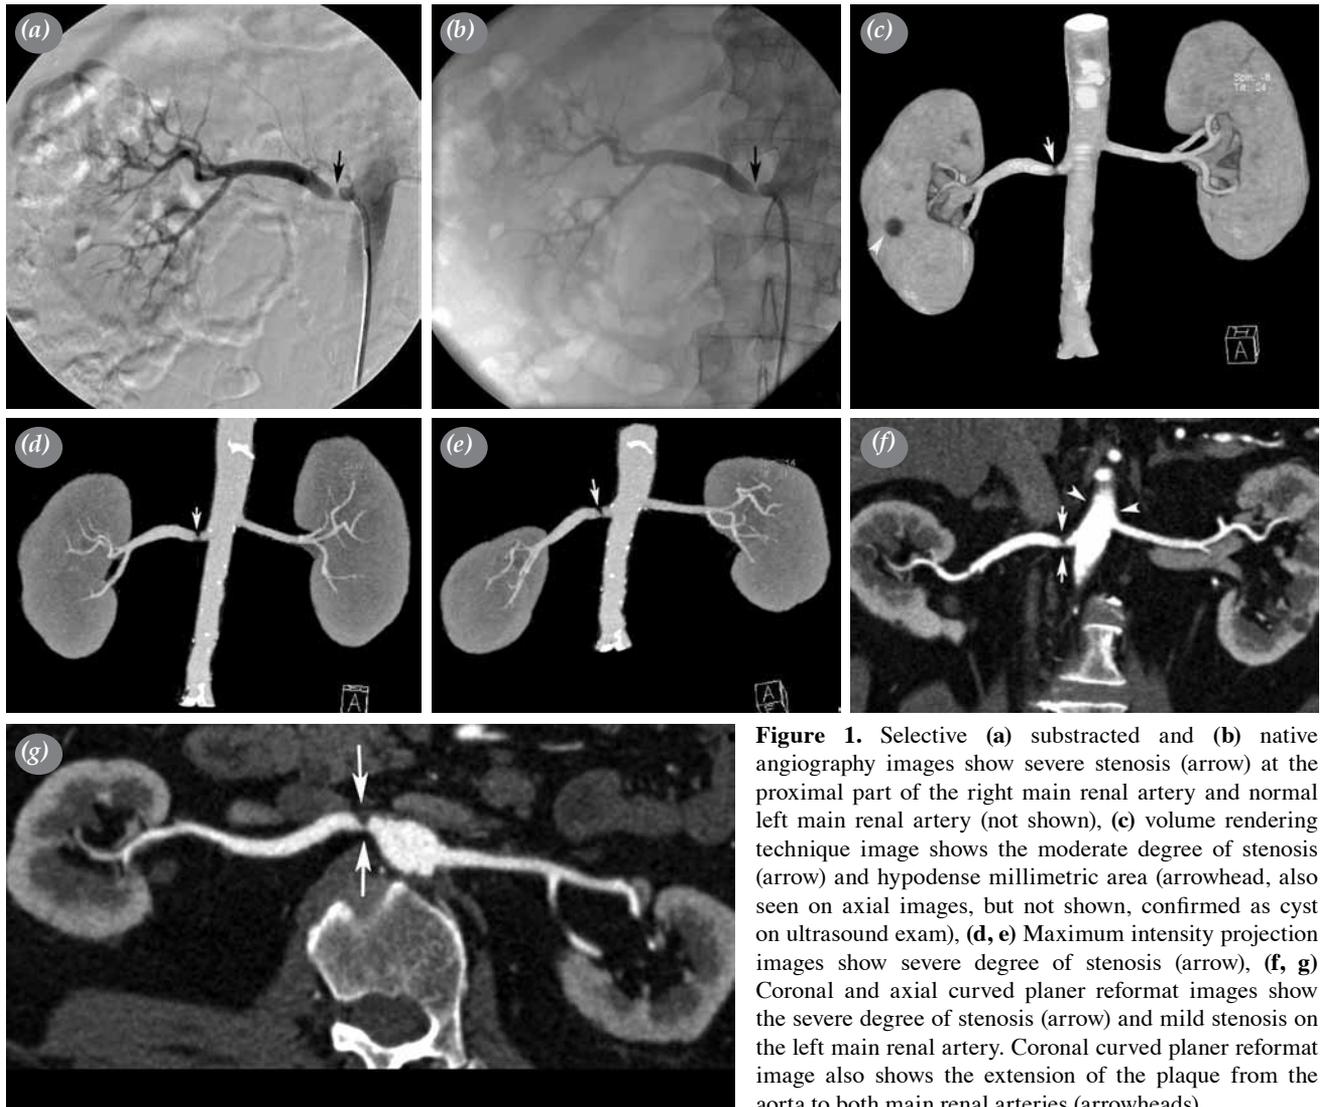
Selective (a) subtracted and (b) native angiography images show severe stenosis (arrow) at the proximal part of the right main renal artery and normal left main renal artery (not shown), (c) volume rendering technique image shows the moderate degree of stenosis (arrow) and hypodense millimetric area (arrowhead, also seen on axial images, but not shown, confirmed as cyst on ultrasound exam), (d, e) Maximum intensity projection images show severe degree of stenosis (arrow), (f, g) Coronal and axial curved planer reformat images show the severe degree of stenosis (arrow) and mild stenosis on the left main renal artery. Coronal curved planer reformat image also shows the extension of the plaque from the aorta to both main renal arteries (arrowheads).
